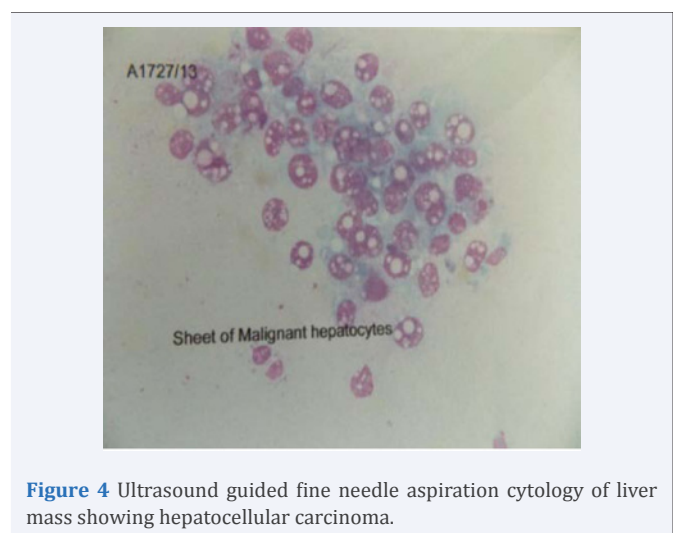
Ultrasound guided fine needle aspiration cytology of liver mass showing hepatocellular carcinoma.
